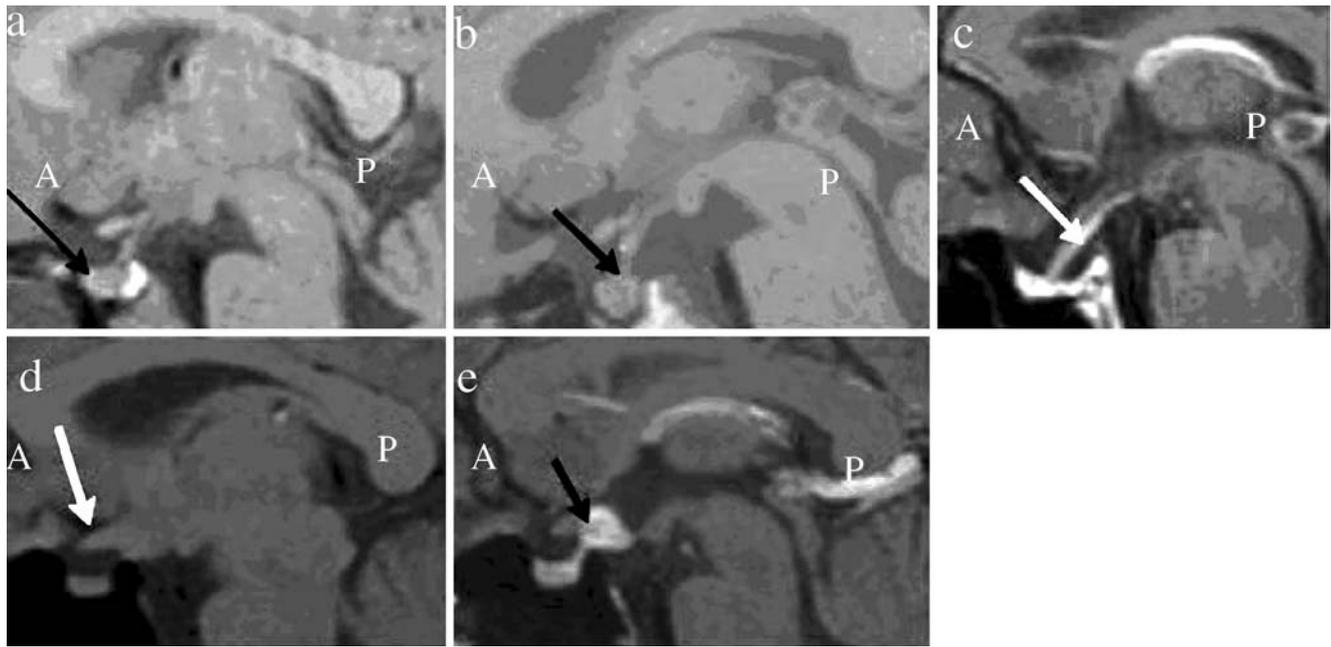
Sagittal T1-weighted images of hypothalamo-hypophyseal structures (A: anterior side; P: posterior side). a Normal image of pituitary stalk in a 10 year old girl: presence of the normal hyperintense signal of the posthypophysis (*black arrow*), and normal height of the anterior pituitary gland. b Absence of normal hyperintense signal of the posthypophysis (*black arrow*) in a patient with CDI. c Mild
